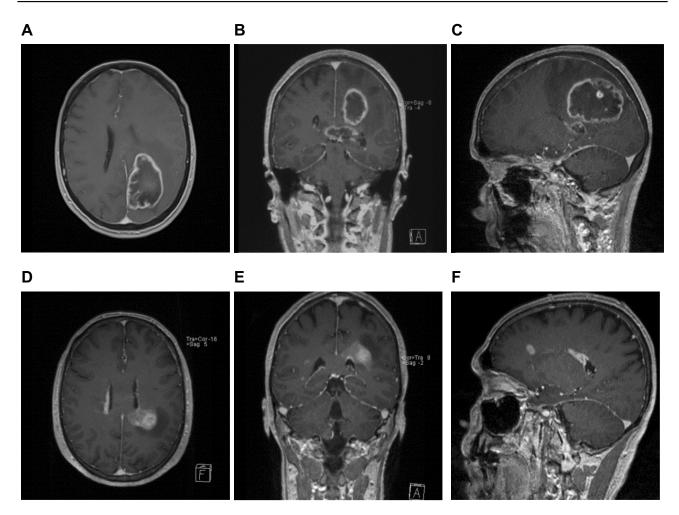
Figure I Magnetic resonance imaging (mri) scan of the neurocranium, gadolinium-enhanced TI-weighted sequences. (A-C) Sibling I. mri axial (A), coronal (B) and sagittal view (C) large mass located in the parieto-temporal lobe, multifocal localization, extension into the corpus callosum and infiltration to the right hemisphere. (D-F) Sibling 2. mri axial (D), coronal (E) and sagittal view (F). Tumor mass located in the parieto-temporal lobe with periventricular, ependymal spread. Multifocal localization, up to the right frontal and temporal regions.
